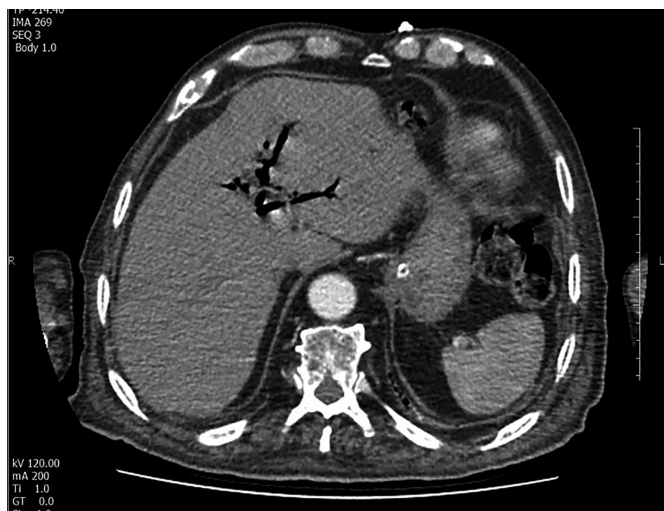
Contrast-enhanced axial CT scan of abdomen. Air is seen in the biliary tract.
